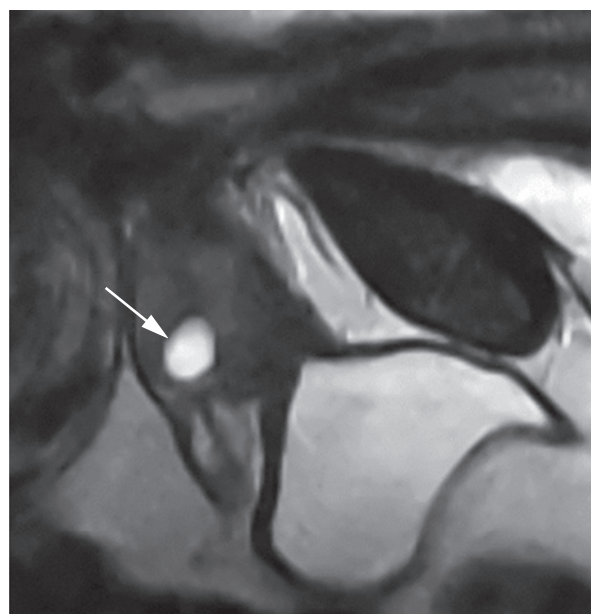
Prostatic utricle cyst (indicated by an arrow) on an MRI T2-weighted image (sagittal section) [7]
